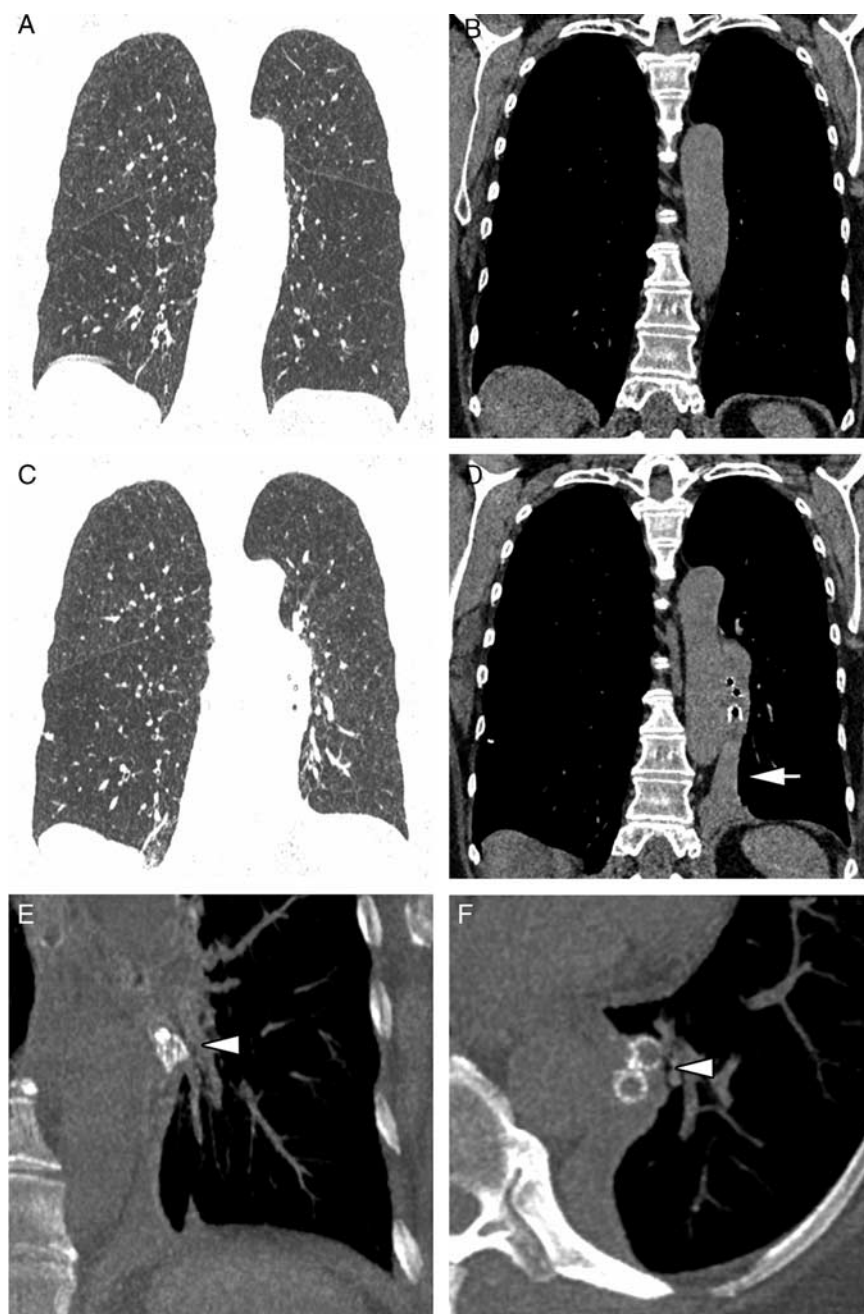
A and B, Endobronchial valve therapy in a 64-year-old woman. CT showed lower lobe–predominant emphysema. Major fissures were > 95% complete in a visual assessment. C and D, Repeat CT 3 months following implantation of endobronchial valves in the left lower lobe (white arrowheads), which resulted in complete lower lobe atelectasis (white arrow). E and F, Magnified maximum intensity projections of the valves implanted into the segmental bronchi of the left lower lobe (white arrowheads indicates valves).
